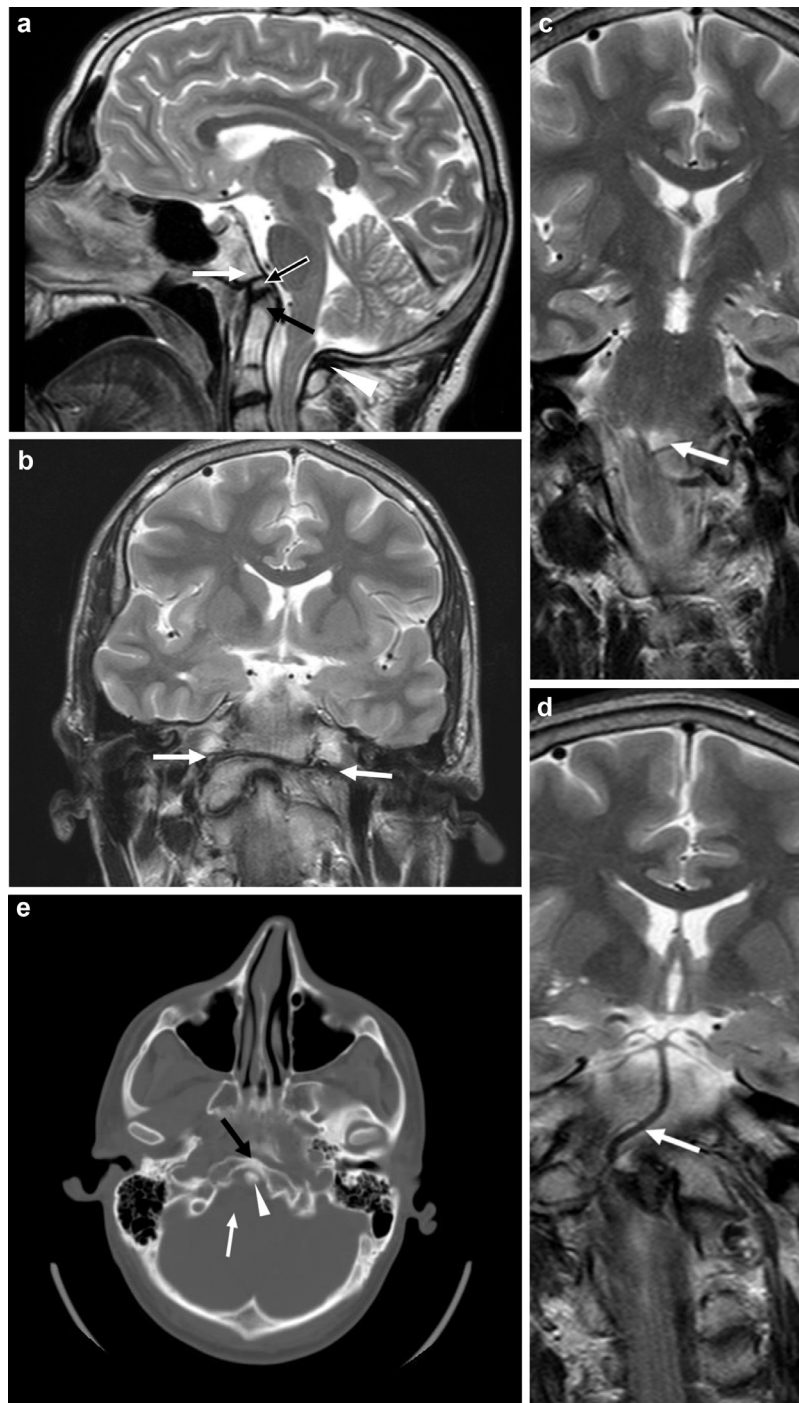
(a) MR sagittal section shows clivus agenesis (white arrow); hypertrophy of the C2 dens (black arrow); and anterior arch of atlas (bicolor arrow); agenesis of the posterior atlas arch (arrow head). (b) MR frontal section shows agenesis of occipital condyles (white arrows) and inversion of atlantooccipital joint axis angle. (c) MR frontal section: medium-lateral dislocation of the medulla oblongata and pons (white arrow). (d) MR frontal section: medium-lateral dislocation of the basilar artery (white arrow). (e) CT transverse section shows C2 dens (arrow head), anterior arch of atlas (black arrow), and agenesis of the posterior atlas arch (white arrow).
